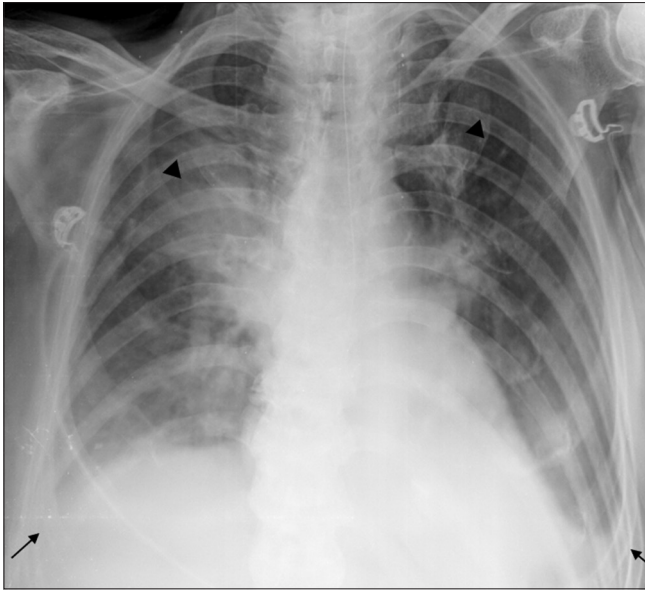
Frontal radiograph of a patient with stroke taken 6 h post thrombolysis shows bilateral, homogenous, upper zone predominant alveolar opacities (arrow heads), and bilateral blunting of costophrenic angles (black arrows) suggesting pleural effusion. Repeat radiograph after 3 days was normal- neurogenic pulmonary edema
